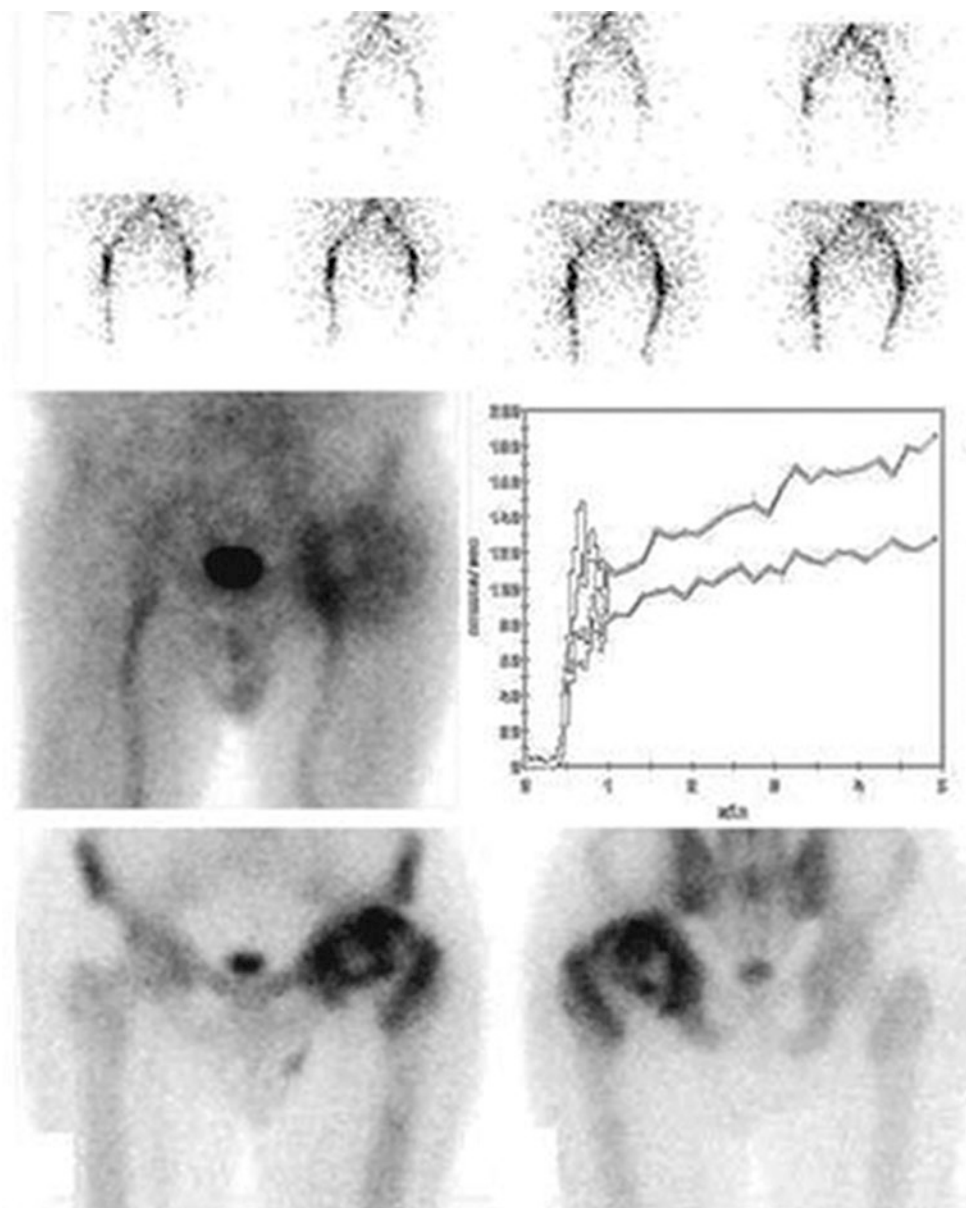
Summary information derived from a three-phase bone scintigraphy performed in a patient with avascular necrosis of left femoral head evaluated in the subacute phase. The eight images in top panel are selected frames from the dynamic acquisition, showing the tracer still in the intravascular phase immediately upon its i.v. bolus injection; the aortoiliac bifurcation is clearly recognized. The activity/time curves in right middle panel correspond to two ROIs defined over the two femoral heads; the higher curve corresponds to the left femoral head, where blood perfusion is now enhanced versus the right femoral head—corresponding to the recovery phase. The left middle panel depicts static
